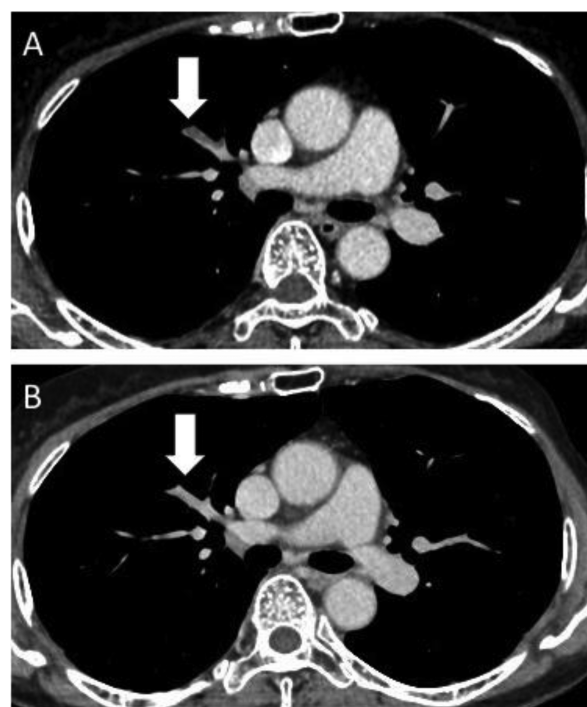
(A) A contrast-enhanced computed tomography scan revealed a defect of the A3 right pulmonary artery (white arrow). (B) After 3 months of anticoagulant therapy with edoxaban, the pulmonary arterial thrombosis had disappeared (white arrow).
